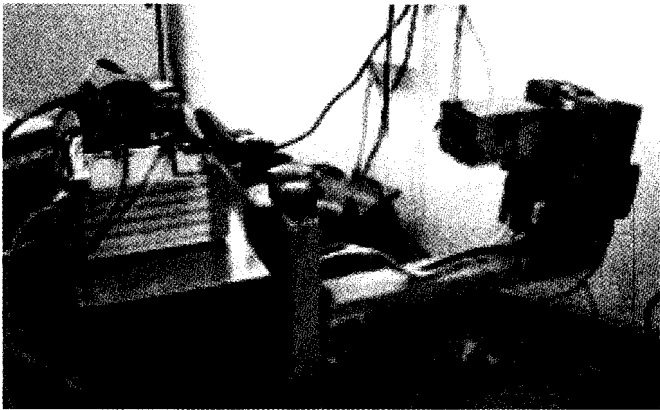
Photograph of the SPECT-TC scanner. (From Gambaccini, [69])
